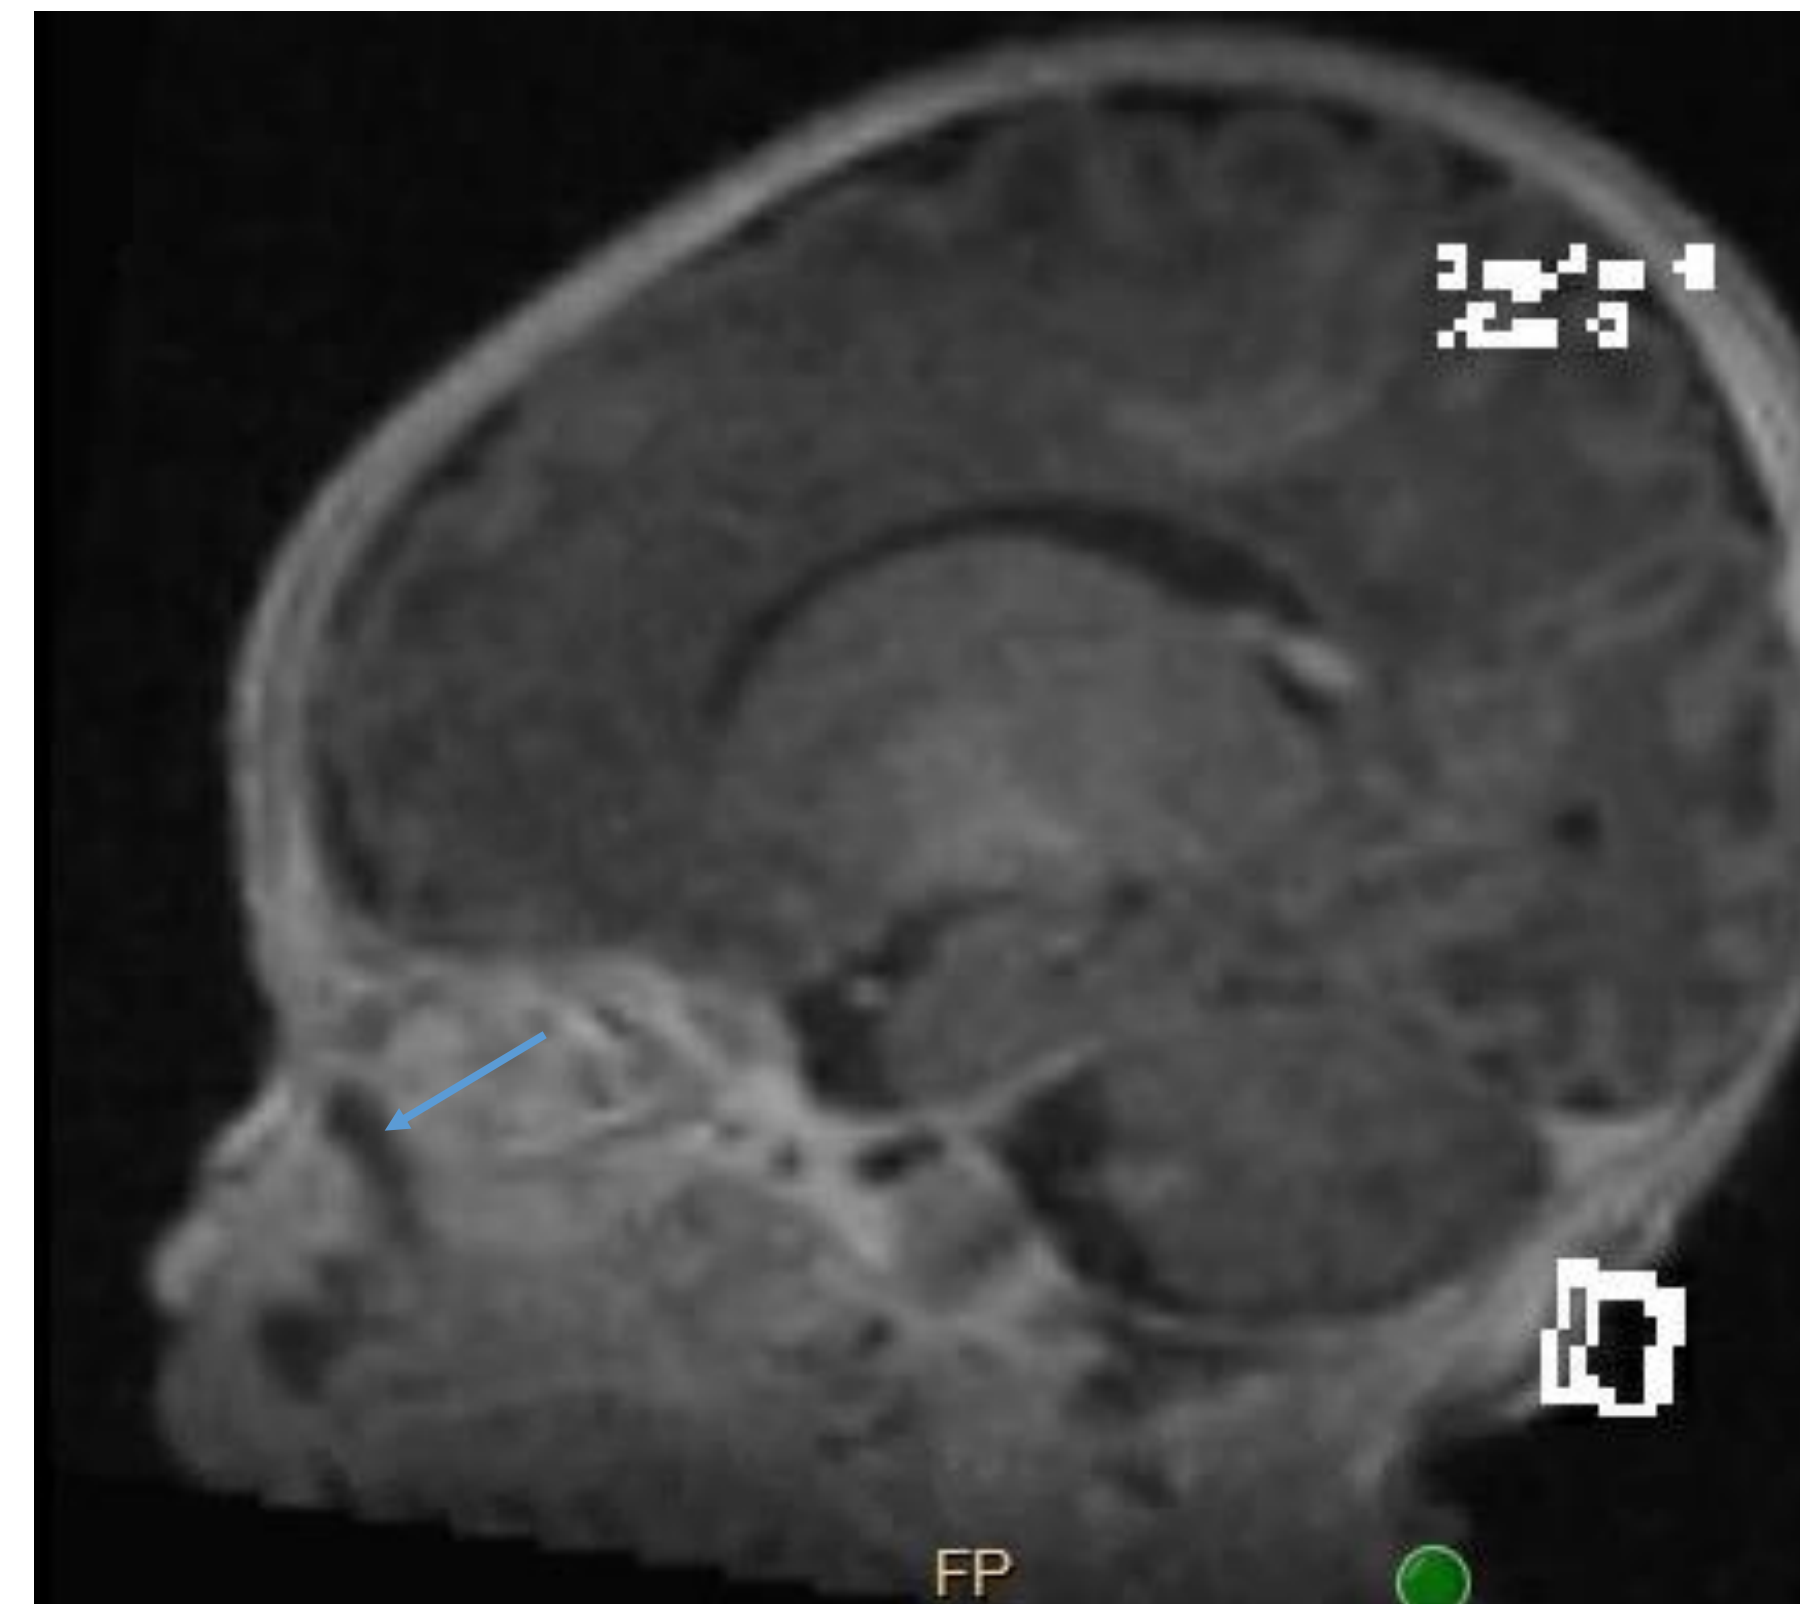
Sagittal MRI showing left periorbital edema without orbital inflammation, prominent fluid-filled nasolacrimal duct, and 2.2 x 0.4 cm abscess in the premaxillary soft tissues.
